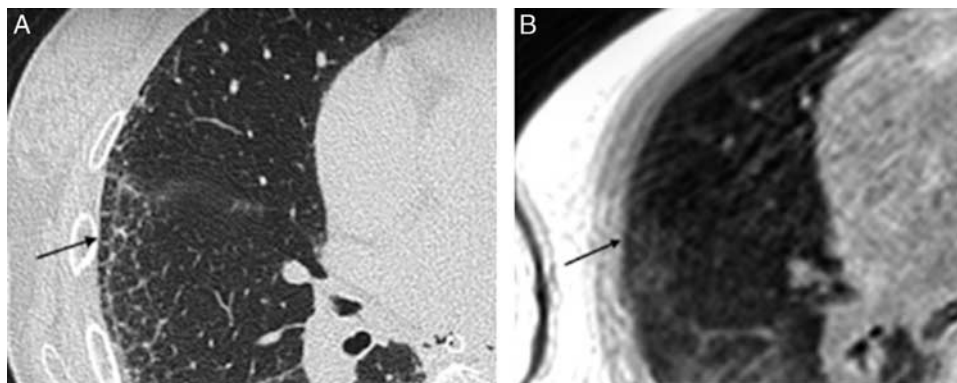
SSc-ILD, particular of the right lung: reticulations assessment. Compared with CT (A), reticulations may be misinterpreted in UTE (B), partially resembling ground-glass opacities (black arrows).
